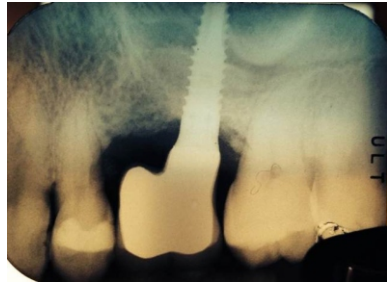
Radiography after 8 months shows good placement of the teeth
